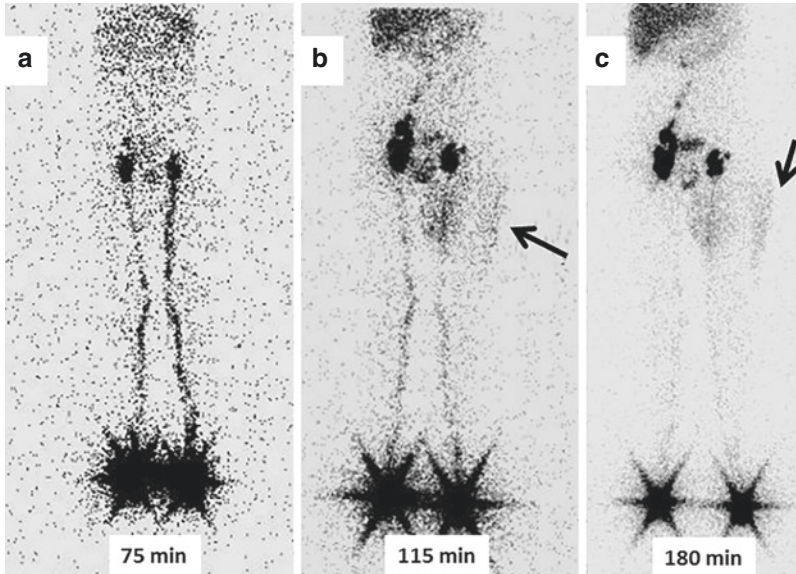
History: A 6-year-old boy presented with lymphedema of the left thigh and buttock that developed 6 months after surgery for a left inguinal hernia. Lymphoscintigraphy was performed following two intradermal injections of Tc-filtered sulfur colloid administered in the interdigital web space between the first and second digits of the feet. Study report: Selected anterior whole-body sweeps starting at 75 min after tracer administration (a) show a symmetrical ascent of tracer from the injection sites through the major lymphatic channels of the lower extremities up to the groin levels. Activity is
